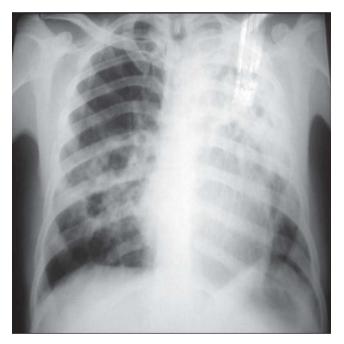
PA chest X-ray upon admission.
